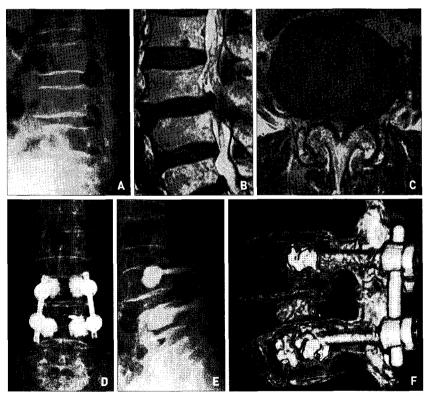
A 64-year-old woman with L3-L4 degenerative spondylolisthesis with severe osteoporosis (T-score on BMD: -3.48). A, B, C: Preoperative simple lateral radiograph and magnetic resonance images showing degenerative spondylolisthesis and severe spinal stenosis at L3-L4 level. D, E, F: Postoperative simple radiographs and 3-dimensional computed tomography scan revealing L3-L4 interbody fusion cages and bone cement augmented pedicular screwings.
